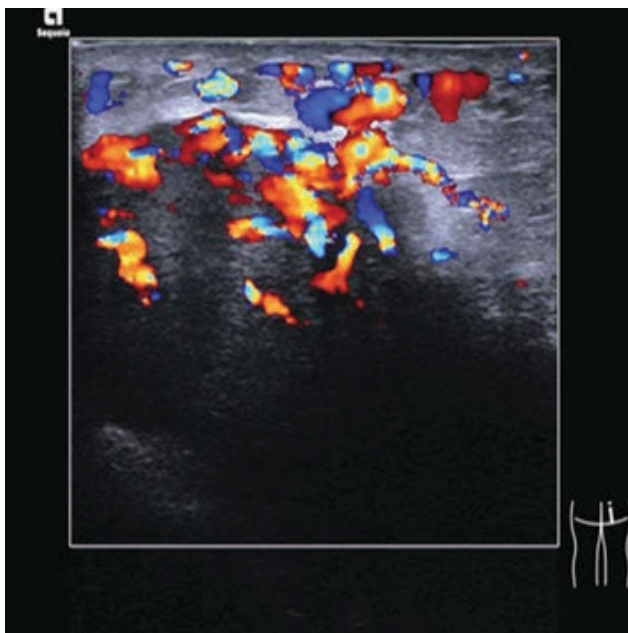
Ultrasonic image.
